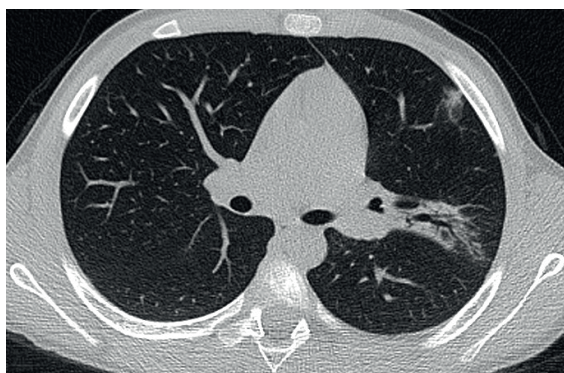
A-10-year-old boy with adenovirus pneumonia. Axial non-contrast enhanced chest CT image shows subpleural ground-glass nodule in the left upper lobe with consolidation and mild bronchiectasis.
